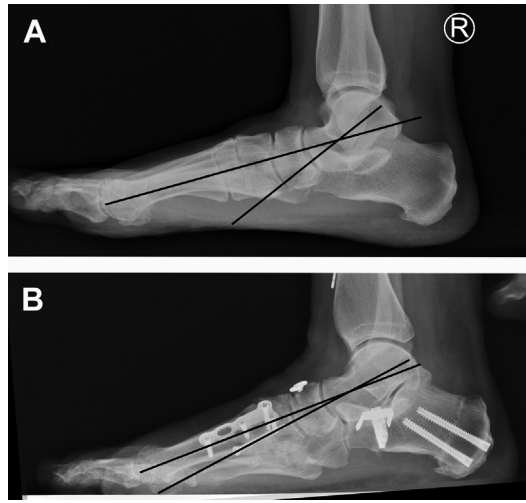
Lateral preoperative radiograph (A) of the patient in Fig. 5 with clear evidence of TN subluxation noted by the incongruence at the TN joint. One-year postoperative correction (B) was excellent and maintained because all sites of instability were appropriately addressed.
